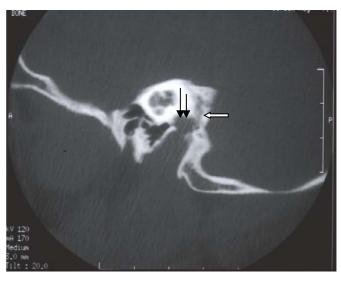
Sagittal CT scan shows erosion of the jugular fossa, where the tumor was located (arrows). Note bone rarefaction related to tumor infiltration (white arrow).
